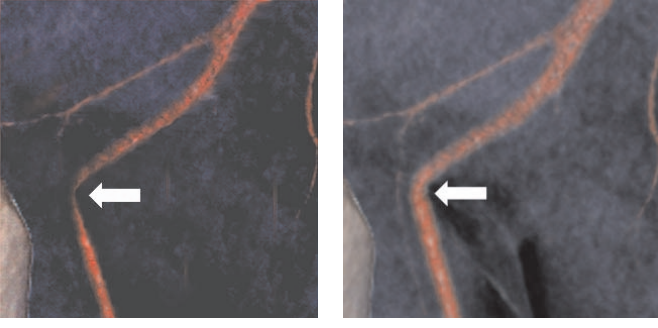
Static TF presets can lead to incorrect conclusions, even for calibrated intensities as in this CT angiography. The renderings were created by commercial DVR software in clinical use. Left: The rendering using the standard TF indicates a stenosis, pointed out by the arrow. Based on this image, an unnecessary surgical procedure was performed. Right: Exploring other TF settings clearly shows that there is no stenosis.
